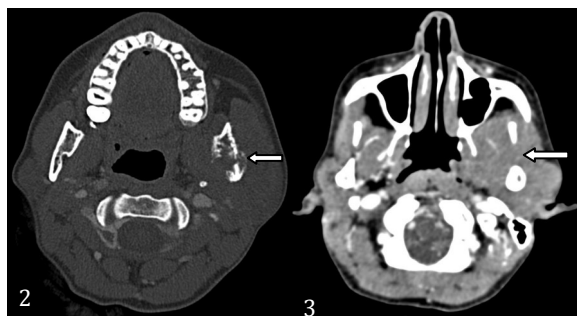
CT axial section- Expansile lytic lesion in left ramus of mandible with periosteal reaction & large soft tissue component demonstrating homogenous enhancement on postcontrast imaging.
